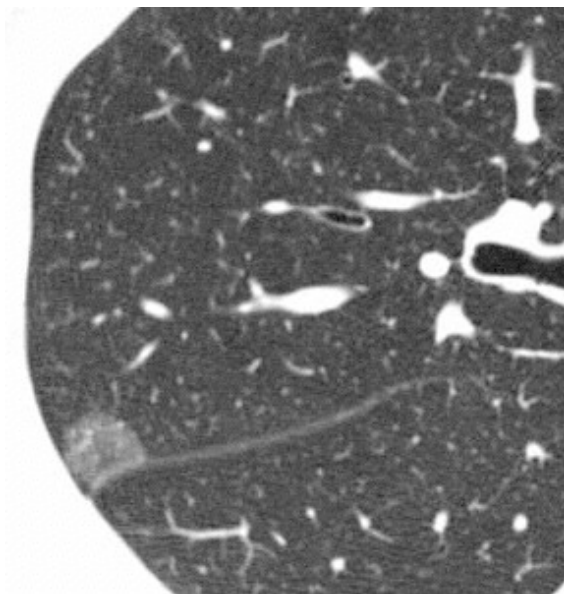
Thin-section CT shows a pure GGO in segment 2 of the right upper lobe.
